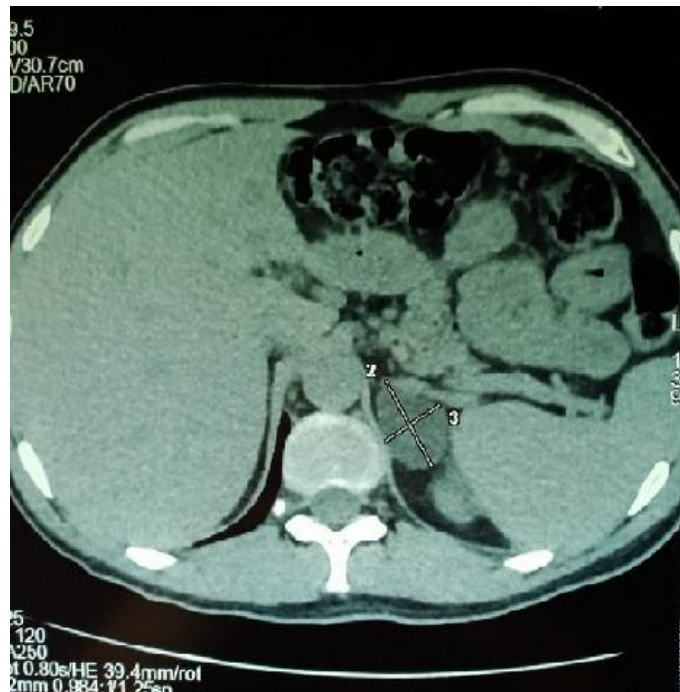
Contrast enhanced CT scan showed a nodular mass measuring 40 x 28 mm with intact capsule located in the left adrenal gland
